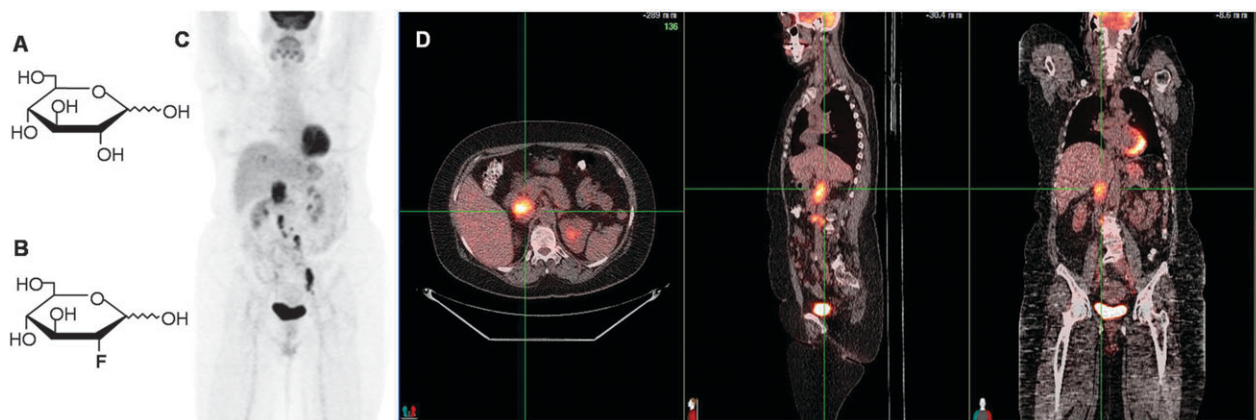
(A) D-Glucose, (B) ^{18}F -FDG, (C) an ^{18}F -FDG PET image and (D) a PET/CT image of a patient with a paradodnal mass secondary to malignant melanoma. Image also demonstrates high ^{18}F -FDG uptake (shown in color scale) in normal brain, heart, and bladder (secondary to radiotracer excretion) overlapped on the underlying anatomical information simultaneously obtained by an X-ray CT scan (shown in the gray scale). Courtesy of Dr Baris Turkbey, Molecular Imaging Program, NCI/NIH.
